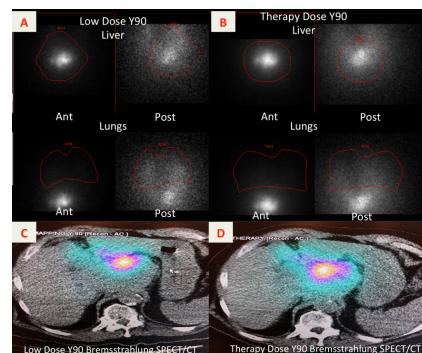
demonstrating a clinical case example in which low-dose Y90 was successfully imaged using planar and SPECT bremsstrahlung (A&C) with similar biodistribution to therapy dose Y90 (B&D).
